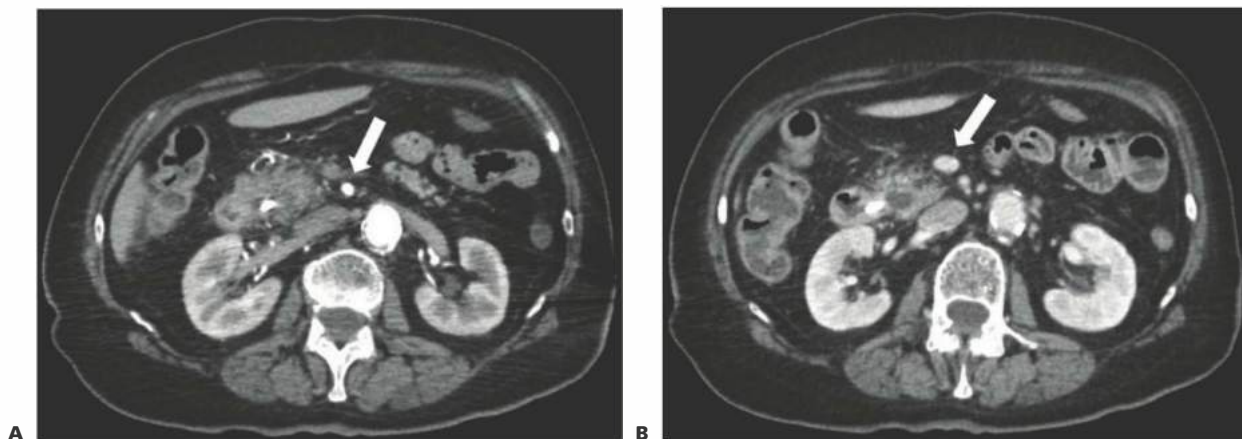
• A CT scan demonstrating the tumor relationship to the surrounding vasculature is required to determine resectability during the preoperative planning phase. A. CT scan of the abdomen with arterial contrast demonstrating clear fat planes around SMA in resectable pancreatic cancer (*white arrow*). B. Venous phase scan demonstrating clear fat planes around SMV (*white arrow*).
